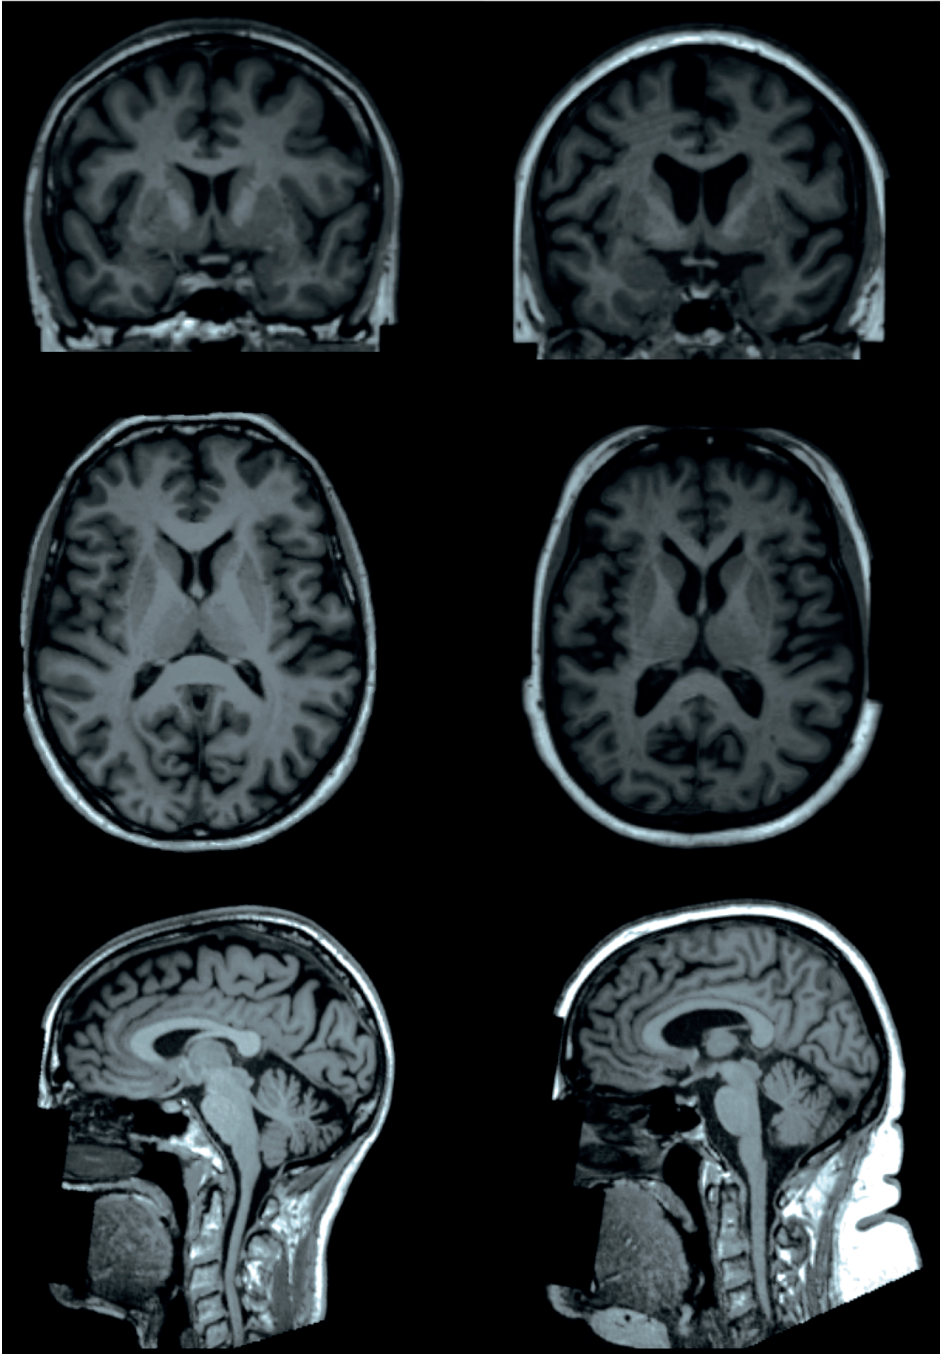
Example of T1-weighted brain MRI scans (coronal, axial and sagittal plane) of two UK biobank participants (both female and 65 years old), one with a body fat percentage of 13% (left) and one with a body fat percentage of 49% (right) showing lower volumes of subcortical gray matter structures in the individual with higher total body fat percentage.
